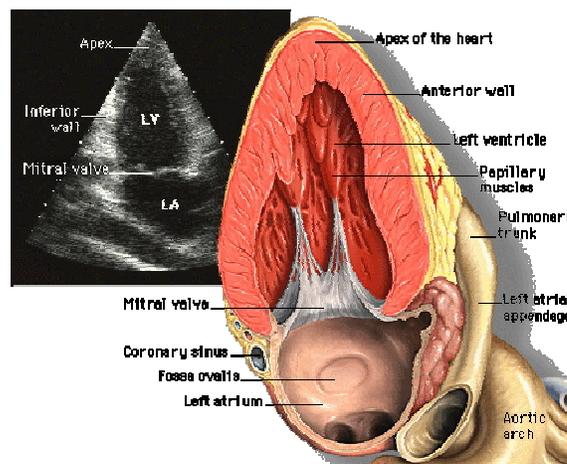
apical 2-chamber view
